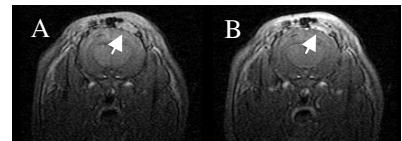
T1-weighted images (A) before and (B) 60s after Gd-DTPA injection. Imaging time is 3 weeks post-surgery. Arrows indicate the implanted VEGF-impregnated soft-tissue construct.
